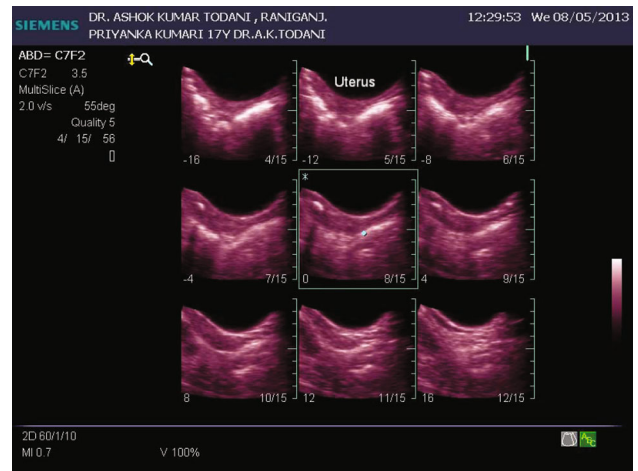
Transabdominal ultrasound uterine multislice
